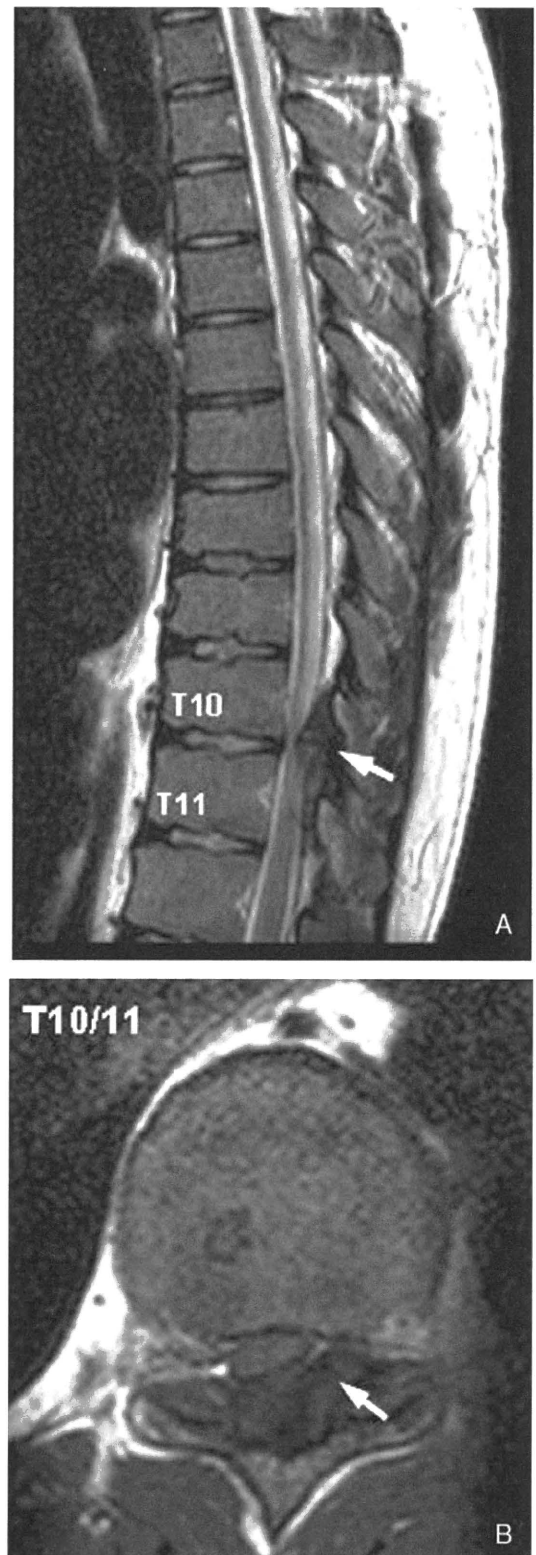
Magnetic resonance (MR) images in patient 1. A, Sagittal T2-weighted MR imaging showing stenosis with compression of the spinal cord by OYL at T10-T11 level (arrow). B, Axial T2-weighted image demonstrating spinal cord compression by OYL situated posterolaterally (arrow).
